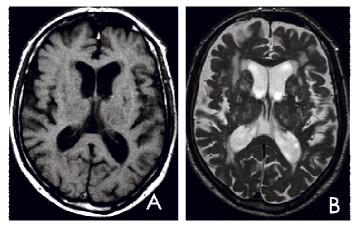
Example of a PVWMH with the charateristic high signal intensity on a T2 weighted image (A) with a low signal intensity on a T1-weighted image (B) (arrow).
